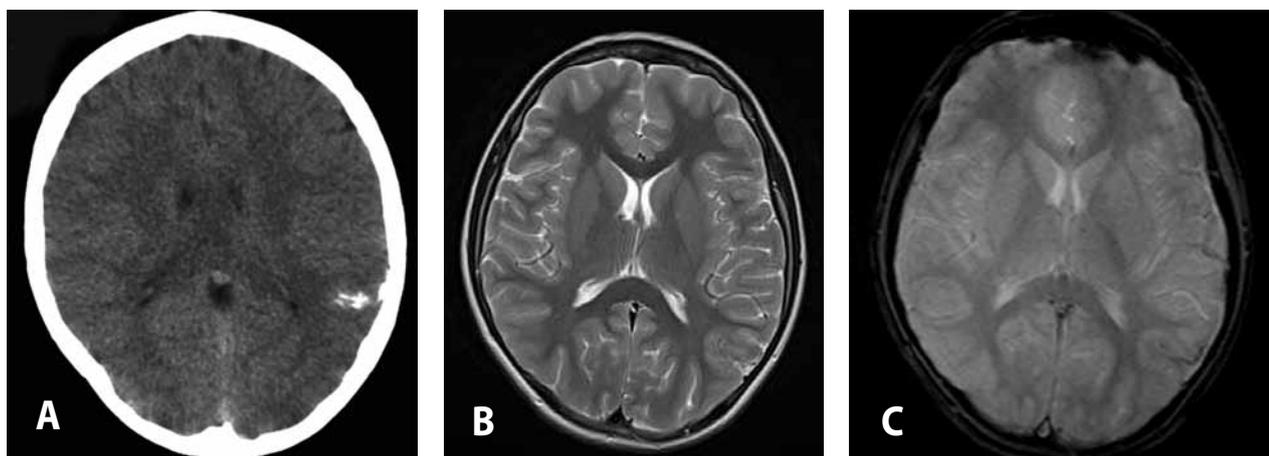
Relatively extensive area of left parietal calcification on CT image in a 11-years-old boy with hypercalcemia and seizure attack (A) associated with completely inconclusive MR imaging – T2W sequence (B) and GRE T2W image (C)
